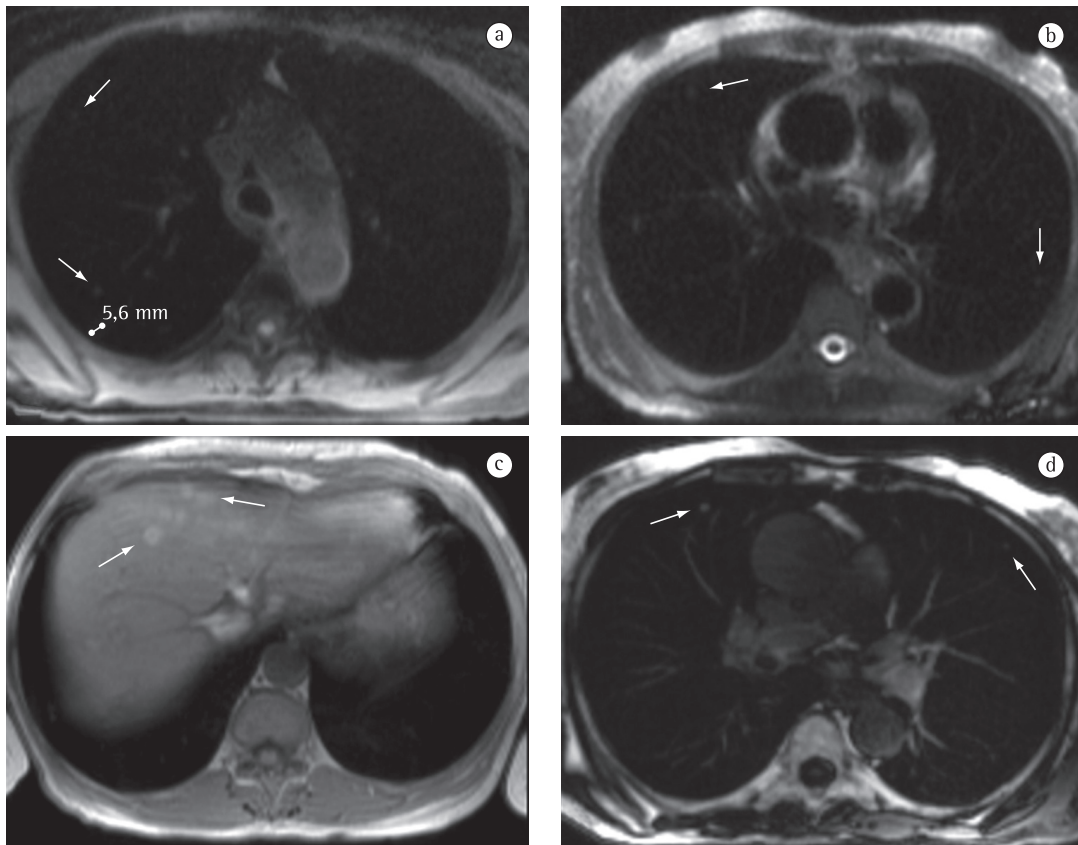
Magnetic resonance images showing metastases of melanoma. Axial T1-weighted images (a and c), axial T2-weighted image (b), and axial contrast-enhanced T1-weighted image (d). In this patient, who was being followed due to malignant melanoma, we can identify various small, peripheral pulmonary nodules—presenting intermediated signal intensity on T1- and T2-weighted images (arrows in a and b)—some of which are smaller than 5 mm (reference nodule measured in a). Contrast enhancement facilitates the identification and definition of the nodules (arrows in d). There are also liver metastases with hyperintensity on T1-weighted images (arrows in c) due to the presence of melanin.
